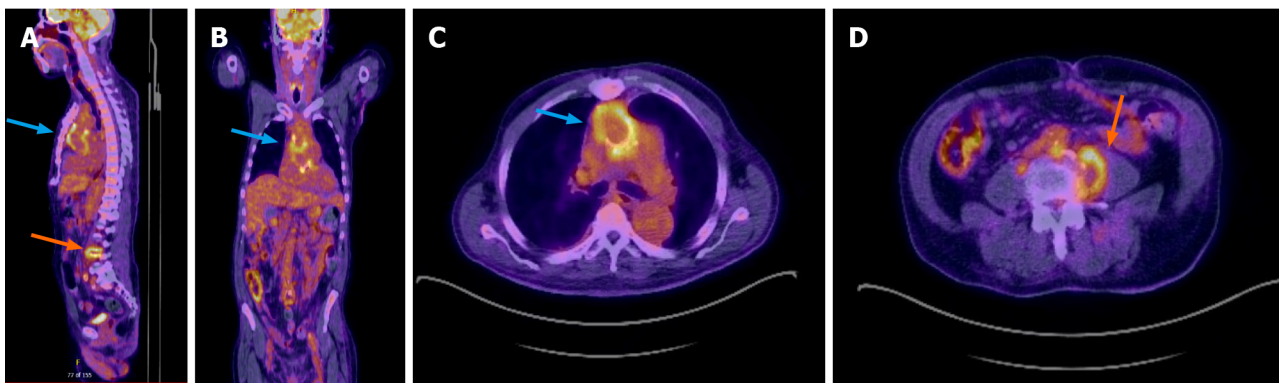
18-fluorodeoxyglucose photon emission tomography/computed tomography in a patient with prosthetic aortic valve endocarditis complicated by septic emboli. For details of clinical presentation, refer to Figure 6. Noted increased ^{18}F -FDG-uptake along the aortic root graft (A-C: Blue arrow) and distant septic foci at the level of L3-L4 with extension of abnormal hypermetabolism into the left psoas muscle consistent with L3-L4 discitis and left psoas muscle abscess (A and D: Orange arrow).
